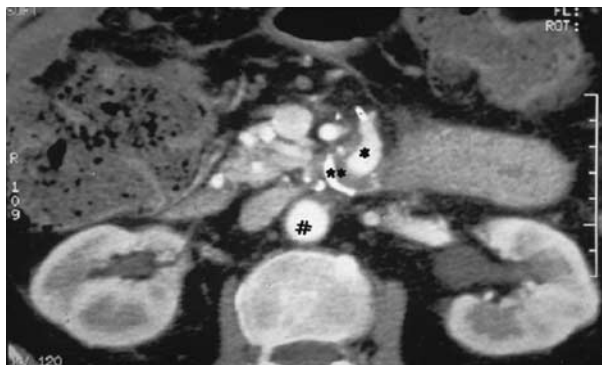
Postoperative CT scanning showing patency of PTFE graft: *graft; thrombosed aneurysm sac; # aorta.
